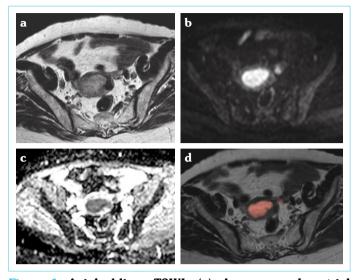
Axial oblique T2WIs (a) shows an endometrial mass of intermediate signal intensity distending the endometrial cavity with the indistinct junctional zone (Stage IB). Axial oblique DWI at the b value of 1000 (b), ADC map (c), and T2/DW fused image (d) suggest deep myometrial invasion (>50%), i.e., Stage IB
